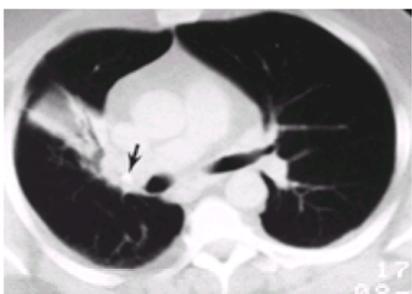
CT demonstrates partial middle lobe collapse. Some patent bronchi are visible. A focus of calcification (*arrow*) is seen centrally near the origin of the middle lobe bronchus. At bronchoscopy, a broncholith composed of calcified and encrusted aspirated vegetable material was removed.
